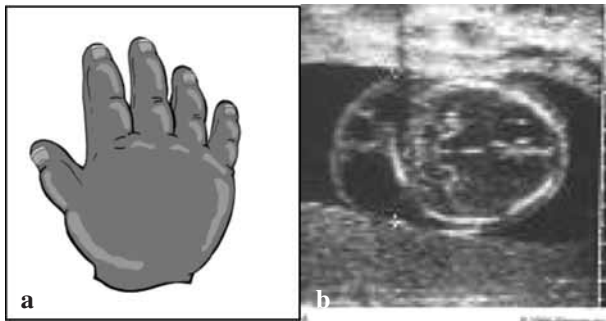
a) Turner syndrome hand with lymphedema and short fourth finger (courtesy by Rudi Bagusat); b) Ultrasound of a cystic hygroma in Turner syndrome.
